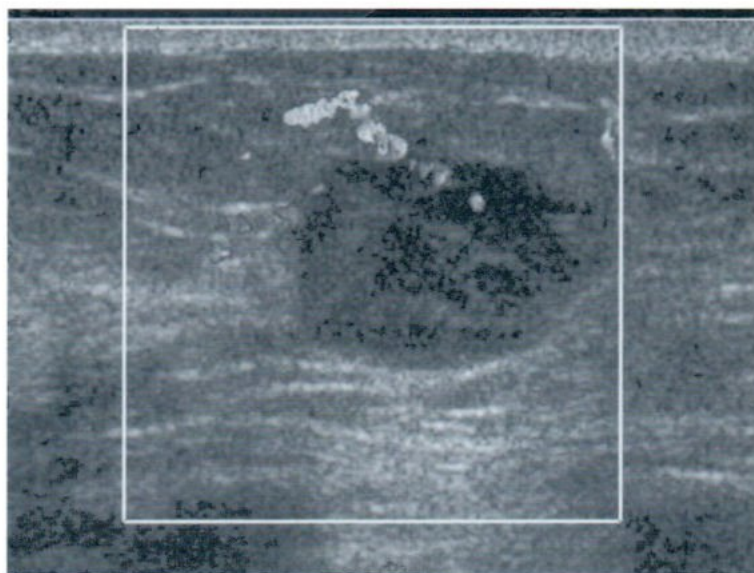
Color doppler study shows hypervascularity with intratumoral and peripheral location of breast mass.
